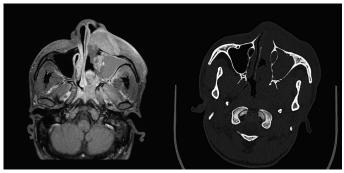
Paranasal sinuses MRI (right) and Facial bones CT scan (left): Solid mass with infiltrating growth pattern and important local destruction
